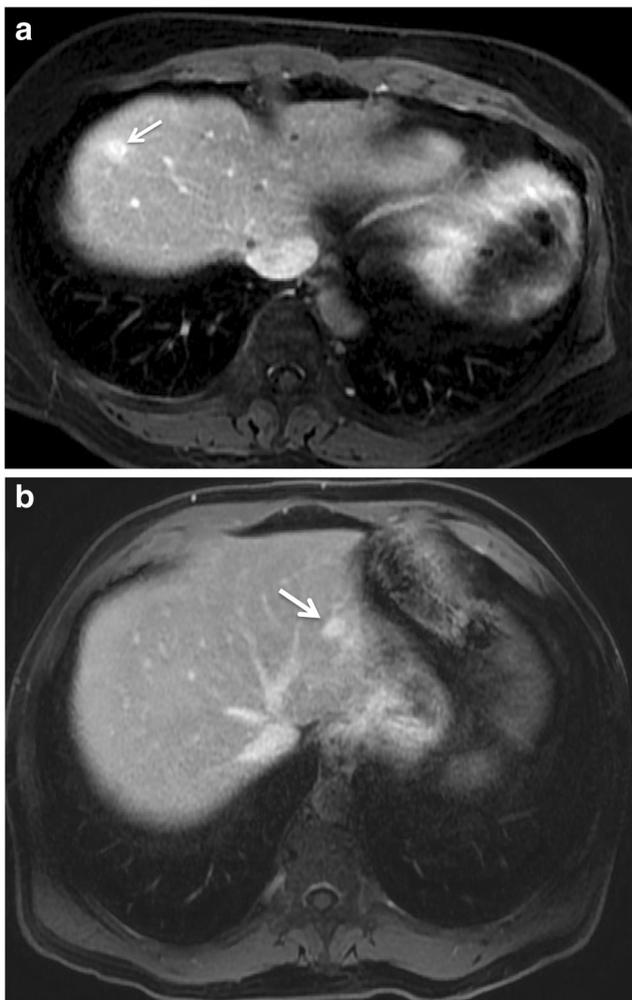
Abdominal MR image demonstrating strong TTE in colorectal liver metastases in (a) a 59-year-old female and (b) a 73-year-old male
